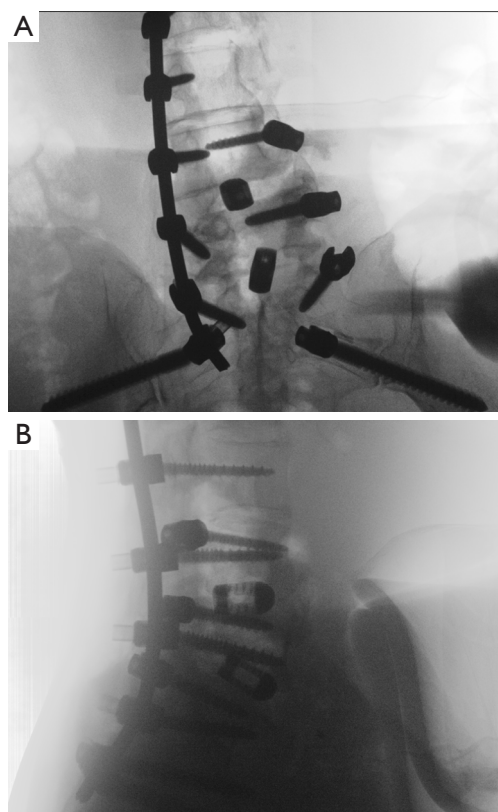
Intraoperative O-arm cone-beam computed tomography of the lumbar spine. (A) Coronal and (B) sagittal cone-beam computed tomography scans obtained intraoperatively to confirm the correct placement of an L5-S1 interbody cage.
